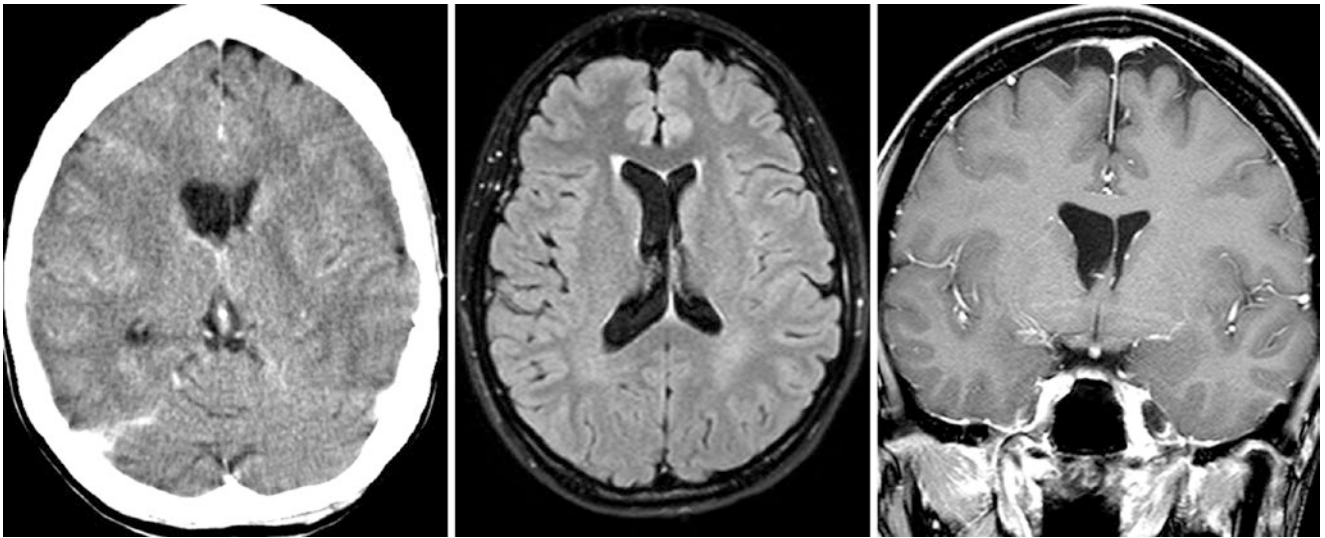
A 38 year old had axial NECT (*left*), axial FLAIR (*middle*), and coronal postcontrast T1WI (*right*) that demonstrated normal, asymmetric enlargement of the body of the right lateral ventricle. The PVWM does not appear to be thinned
